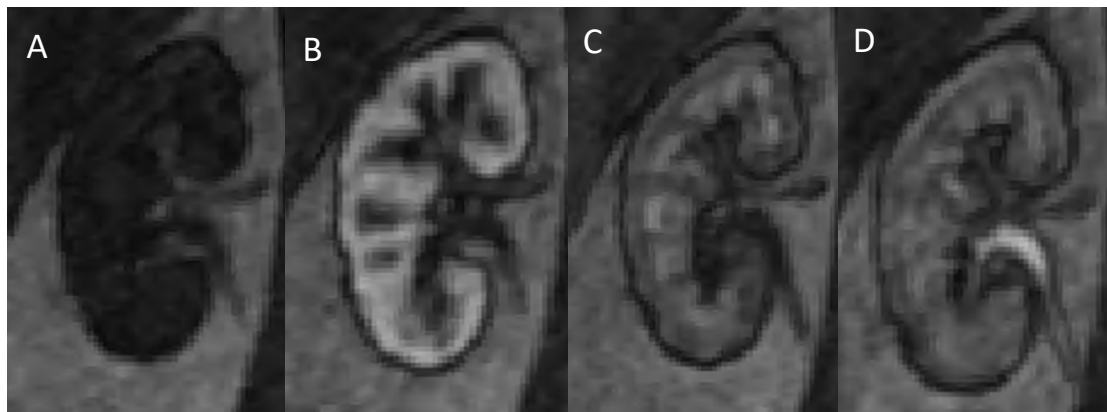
DCE MRI images of right kidney acquired at different time points before and after administration of contrast agent
